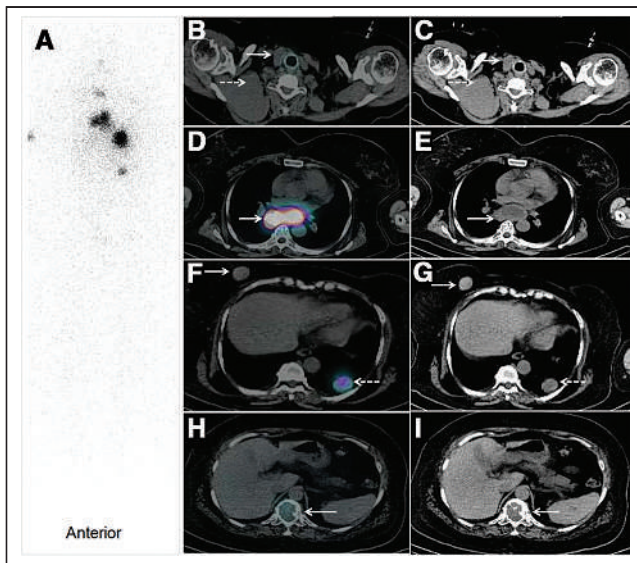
Whole-body radioiodine planar (A), transaxial SPECT/CT (B, D, F, and H), and CT (C, E, G, and I) images showing iodine-avid residual tissue in thyroid bed (B and C, solid arrows), multiple cervical and mediastinal lymph nodes (D and E, arrows), bilateral lung nodules (F and G, dashed arrows), and a few non-tracer-avid cervical lymph nodes (B and C, dashed arrows), right-breast lesions (F and G, solid arrows), and skeletal lesions (H and I, arrows).
